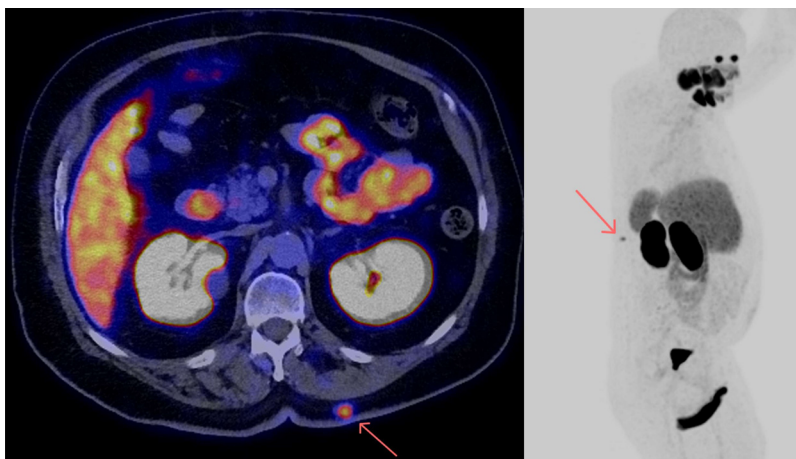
3-year follow-up PSMA PET-CT showing stable lesion (red arrow) at the L1 level with similar PSMA intense avidity to Figure 1 with the axial hybrid PSMA PET-CT (left) and whole-body PET maximum intensity projection image on right anterior oblique projection (right) (Color version of figure is available online).
